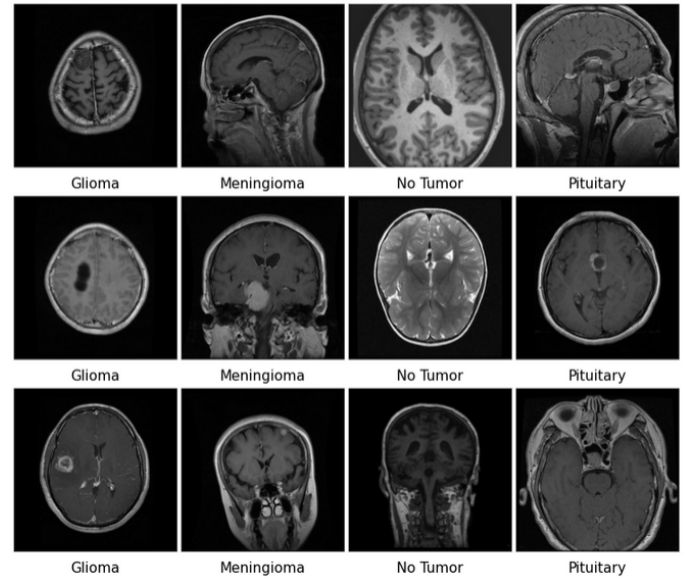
Representative MRI images for the four classification categories: glioma, meningioma, pituitary tumor, and no tumor.
